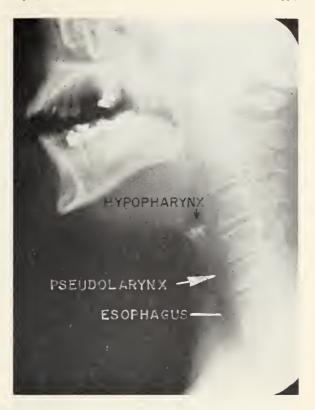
A radiograph of a laryngectomized person phonating the vowel "ah." The arrow indicates the constriction of muscle fibers which is called the pseudolarynx. In this subject the pseudolarynx extends from the level of the lower margin of the fourth cervical vertebra to the level of the lower margin of the sixth cervical vertebra.
